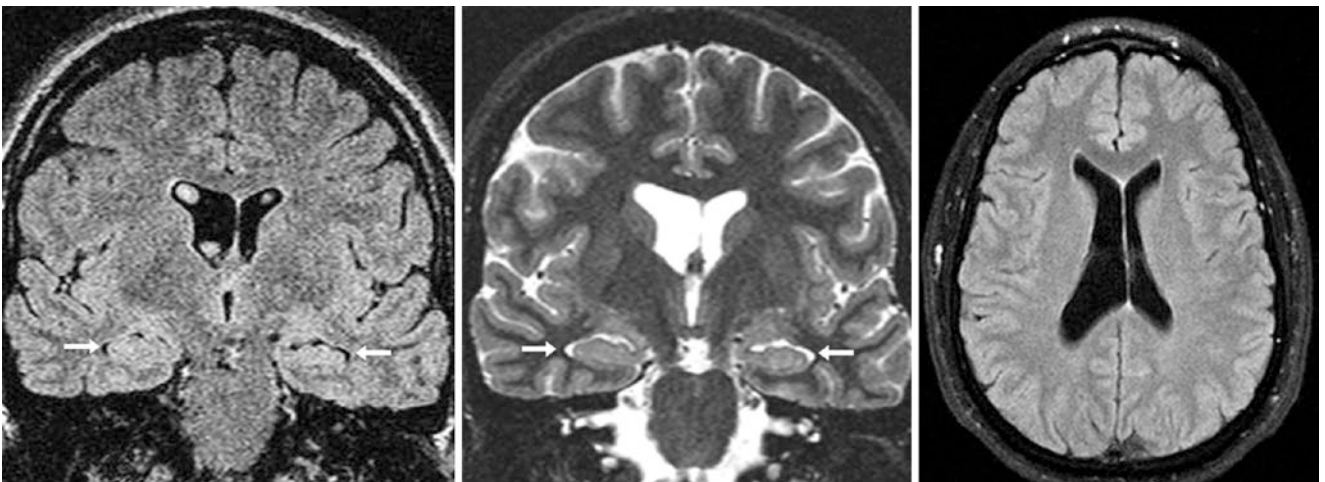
A 37 year old underwent coronal FLAIR (*left*) and T2WI (*middle*) that demonstrated asymmetric enlargement of the body of the right lateral ventricle without enlarged temporal horns (*arrows*). Axial FLAIR images (*right*) are also shown. This should not be mistaken for PVL because there is no significant PVWM thinning
